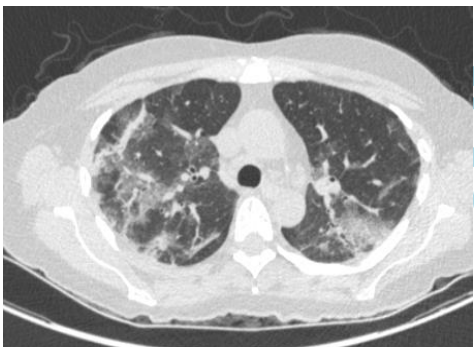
Progression of CT scan findings
